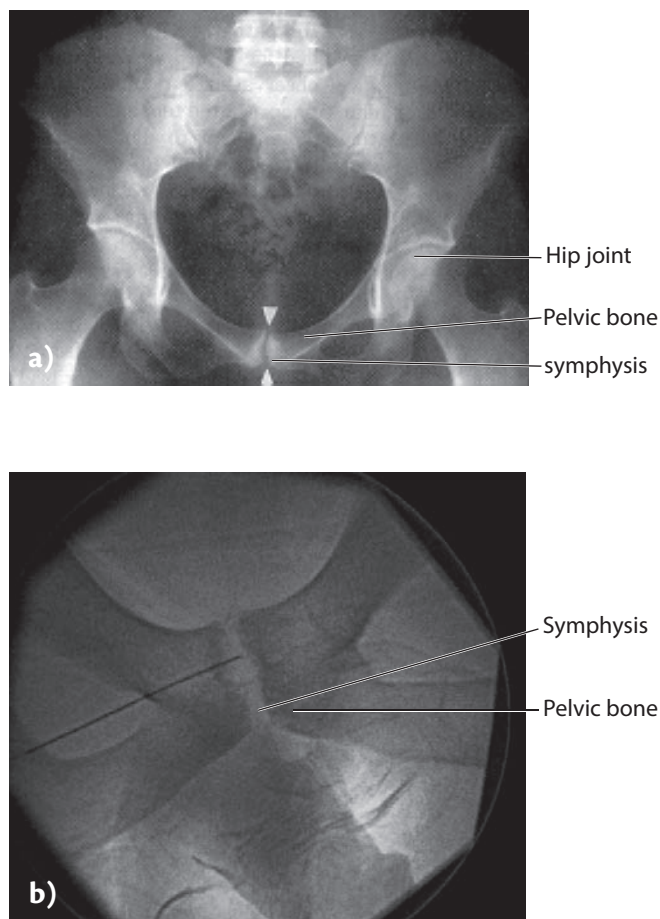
Changes may be seen in the skeleton around the symphysis (osteitis symphysis pubis). a) X-ray picture of the pelvis. The arrows show changes in the symphysis on the pubic bone, i.e. the point where the left and right pubic bones meet at the front of the pelvic girdle; b) if needed a corticosteroid injection can be given into the space between the symphysis; fluoroscopy (use X-ray to obtain images of internal structures through the use of a fluoroscope) should then be used to check that the injection is given in the correct place. Notice the bony changes (erosion).
